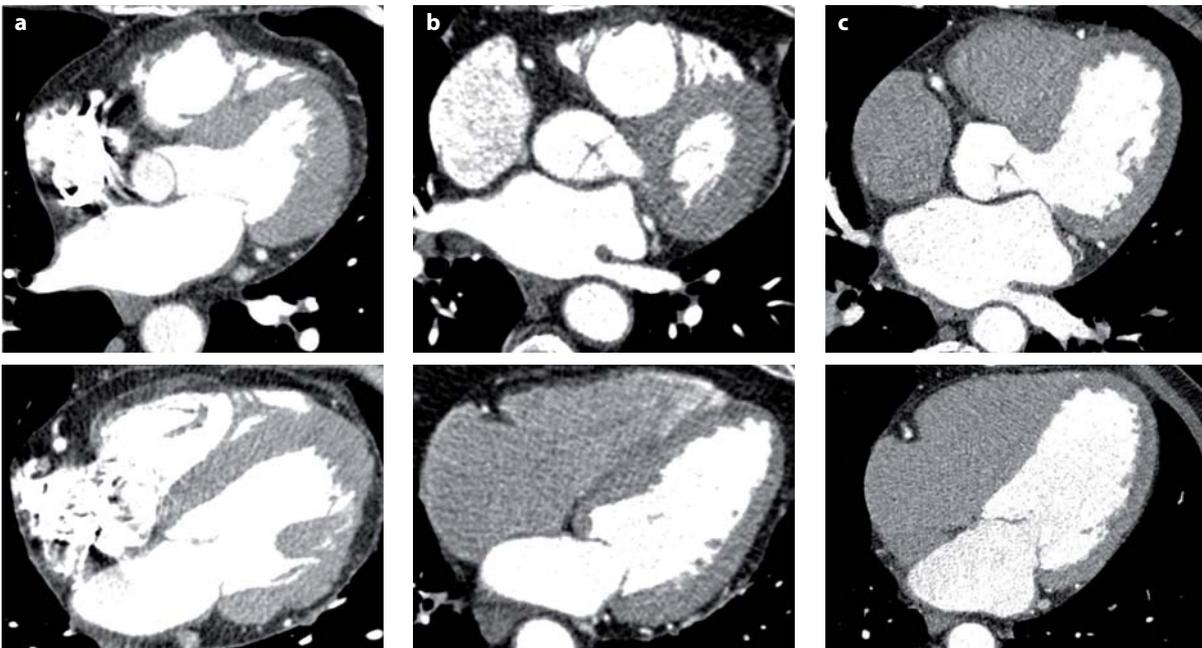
a-c. With more modern CT scanners and shorter scan times, the amount of contrast media can be reduced. The scan time for the entire heart lasts around 40, 20, or 10 s for a 4-slice (a), 16-slice (b), or 64-slice CT (c), respectively. Flow rate and contrast volume changes accordingly: 120 ml with 3 ml/s (a), 100 ml with 4 ml/s (b), and 60 ml with 5 ml/s (c). In addition, artifacts in the right atrium may be avoided and selective enhancement of the left ventricle and the coronary arteries can be achieved
